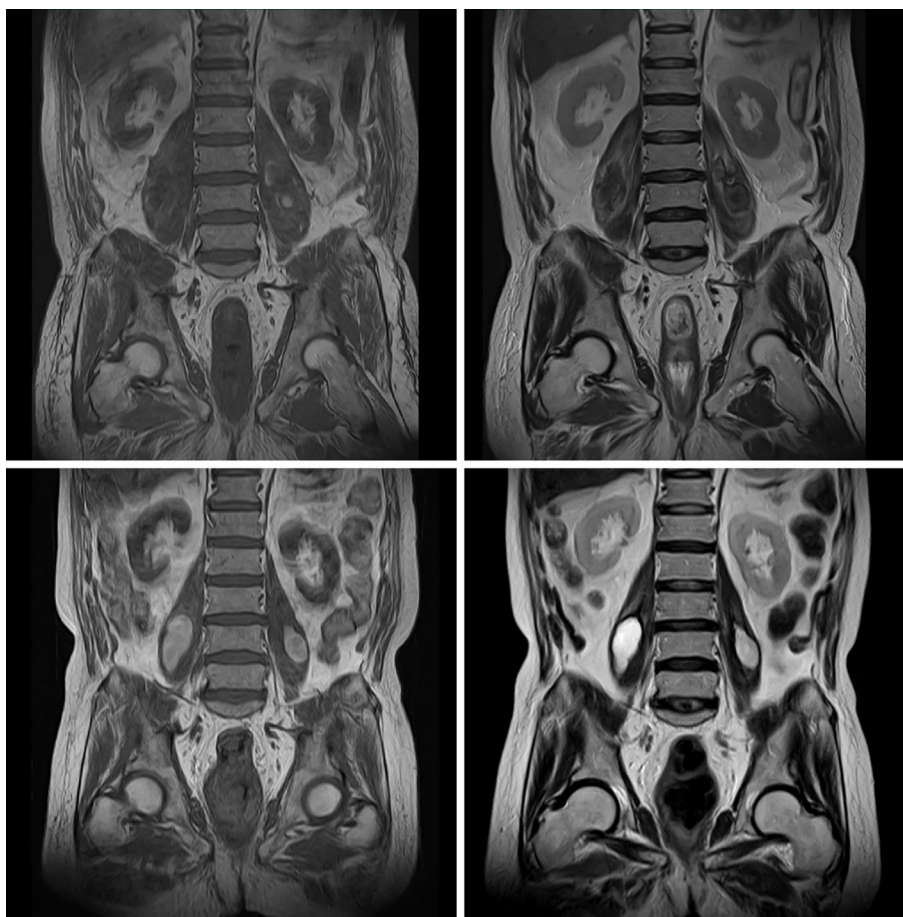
Magnetic resonance imaging showed evidence of bilateral iliopsoas hematoma. T1-weighted images on the left side, T2-weighted images on the right side. MRI findings at Day 6 (upper row) revealed space occupying lesions (SOLs) in the bilateral iliopsoas with a low-intensity area surrounded by a high-intensity area on both T1- and T2-weighted imaging. MRI at Day 27 (lower row) showed high-intensity SOLs in the bilateral iliopsoas on both T1- and T2-weighted imaging, which was consistent with chronic hematoma.
